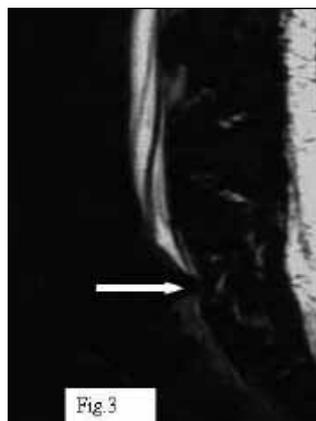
MRI of case 16: Sagittal T2-weighted MRI demonstrated complete spinal canal stenosis due to a massive calcified disc herniation at the L5-S1 level (long arrow) and thecal sac ending at the same level. The sacral spinal canal was free (small arrow).
